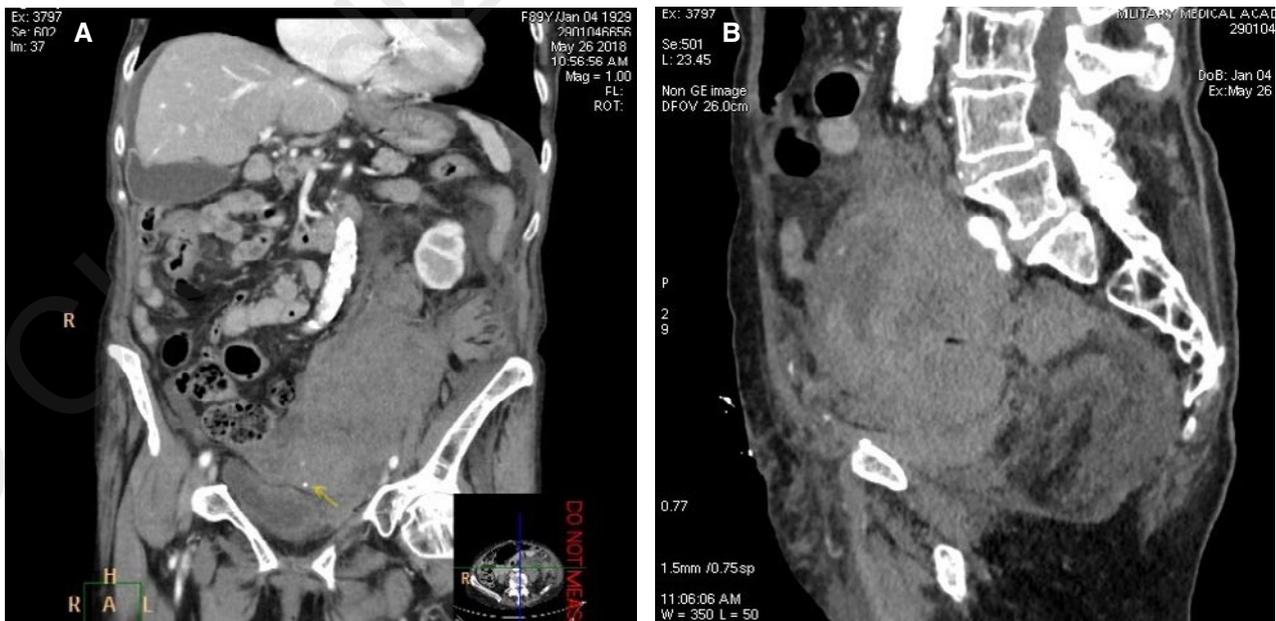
Contrast CT – large retroperitoneal hematoma with medial dislocation of the viscera and active bleeding (arrow).
